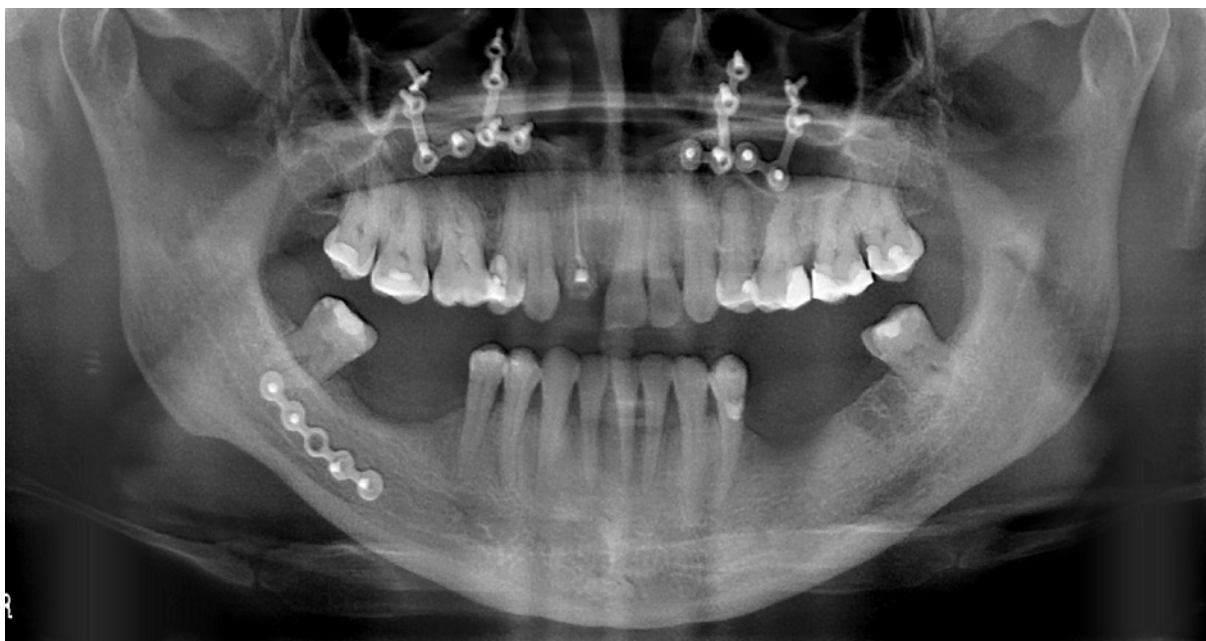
Panoramic radiograph with almost entirely healed mandibular bone
